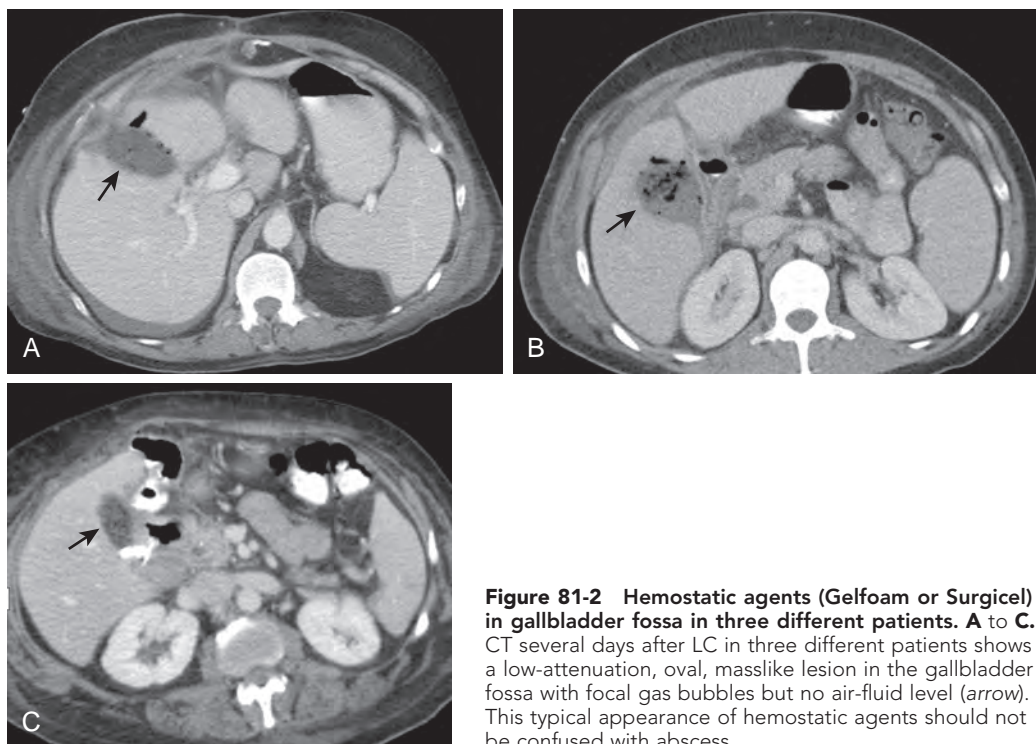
Hemostatic agents (Gelfoam or Surgicel) in gallbladder fossa in three different patients. A to C. CT several days after LC in three different patients shows a low-attenuation, oval, masslike lesion in the gallbladder fossa with focal gas bubbles but no air-fluid level (arrow). This typical appearance of hemostatic agents should not be confused with abscess.
